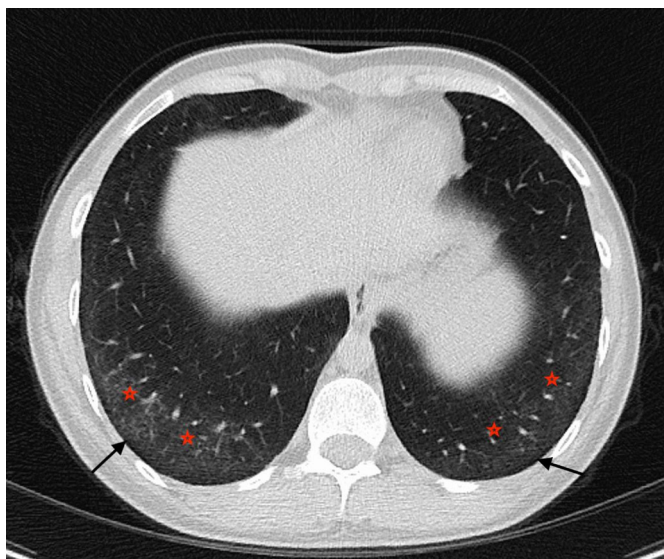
Basal reticular and ground glass opacities (red stars) with subpleural sparing (black arrows) are observed on axial chest CT image
